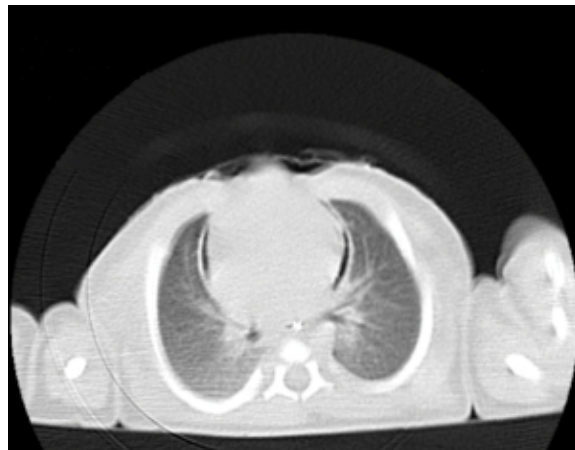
Chest CT findings.
